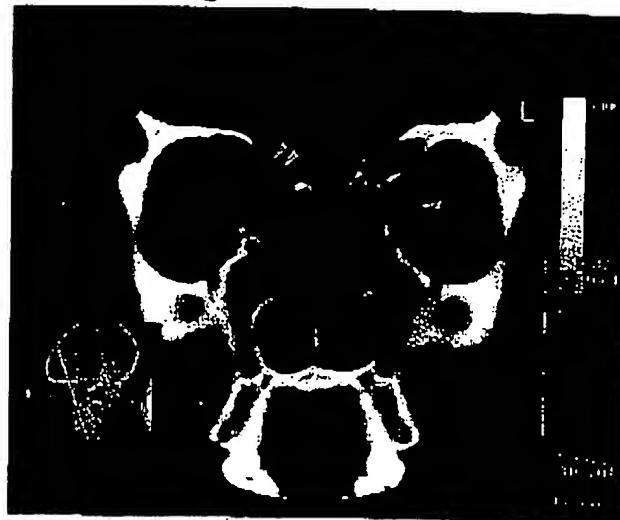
Coronal CT scan of a patient after endoscopic surgery for allergic fungal sinusitis. Violation of mucosa and dura of the anterior cranial fossa resulted in encephalocele formation (double arrows), whereas violation of the contralateral periorbita produced trauma and fibrosis of the medial rectus muscle (single arrow).
